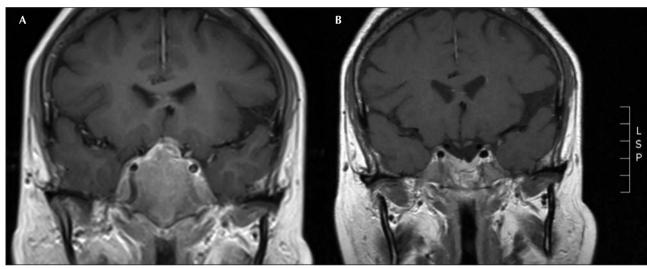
A: Initial magnetic resonance imaging (MRI). B: MRI after surgery.
